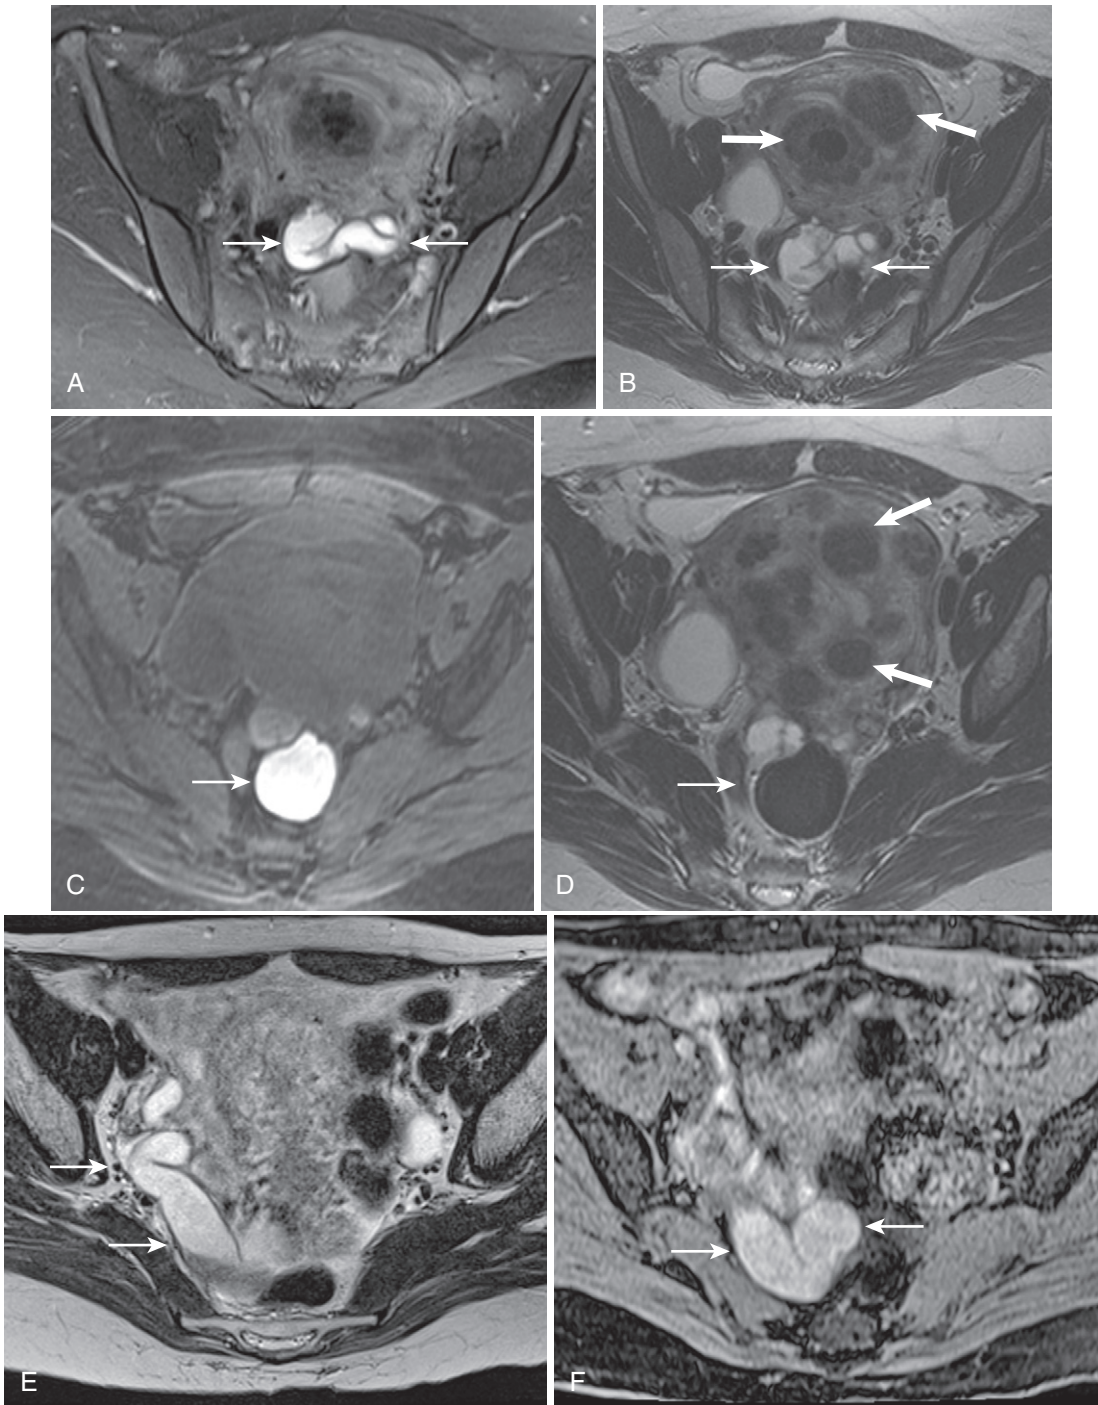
Hematosalpinx. Tubular morphology, T1 hyperintensity, and periuterine location are all easily appreciated in this case of hematosalpinx (*thin arrows* in A and B) showcased on axial T1-weighted fat-suppressed (A) and T2-weighted (B) images. C and D, An adjacent endometrioma in the cul-de-sac (*arrow*) demonstrates the typical signal characteristics—T1 hyperintensity (C) and shading, or T2 hypointensity (D). Note the multiple incidental intramural fibroids (*thick arrows* in B and D). E and F, Tubular morphology is even better demonstrated in a different patient with dependent-lying concentrated blood products (*arrows*) exhibiting shading on the T2-weighted image (E) and hyperintensity on the T1-weighted fat-suppressed image (F).
